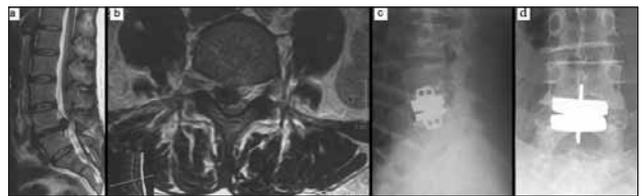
The preoperative MRI of the patient showed recurrent disc herniation and degenerative disc disease at the L4-5 level (A,B). The postoperative plain radiographs show the Total Disc Replacement (C,D).
